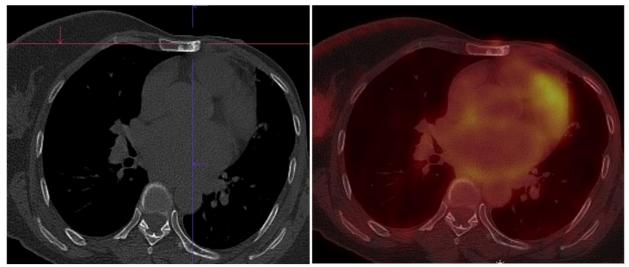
A 57-year-old female with a history of left mammary ductal carcinoma is currently under suspicion of recurrence based on clinical loco-regional evidence, notably the presence of an inflammatory left parasternal nodule. PET has failed to diagnose osseous extension of the cancerous disease. Bone scan has shown afterwards an increased Tc-MDP uptake in the sternum.
